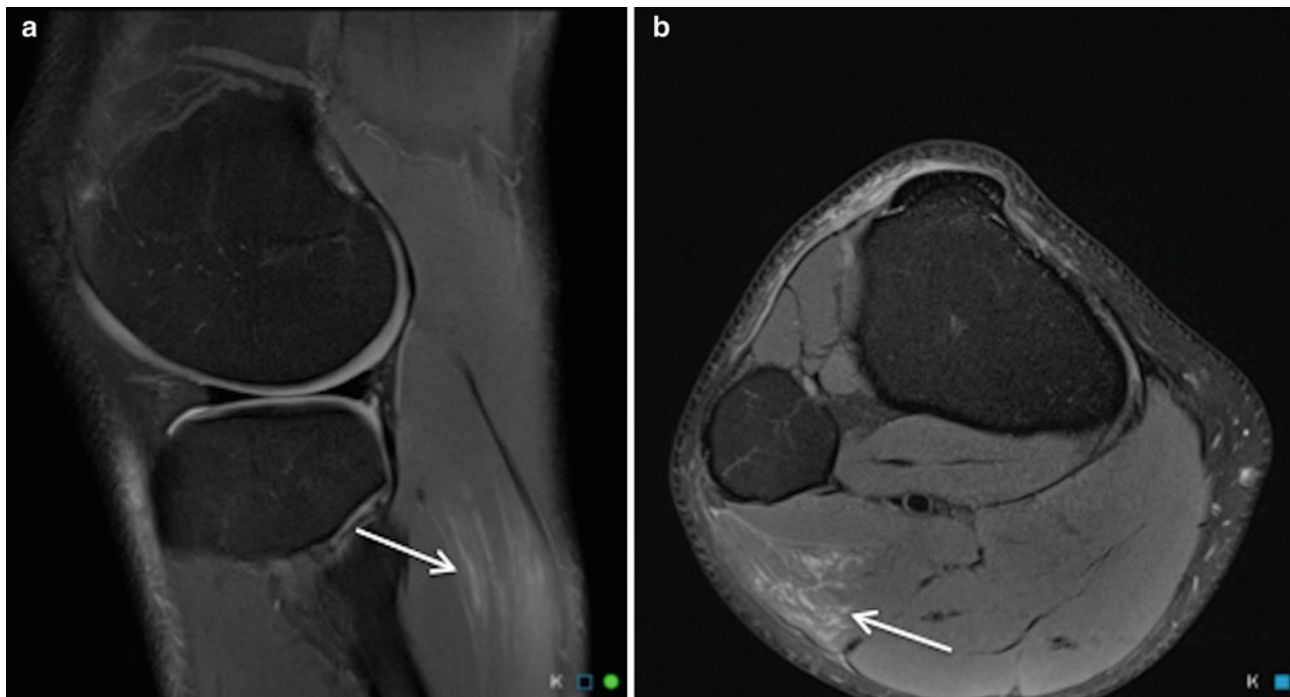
Calf strain. Sagittal (a) and axial (b) proton density weighted MR images with fat saturation (b) show a grade 1 injury of the lateral head of gastrocnemius in a professional rugby league player, with feathery intramuscular oedema but no muscle fibre discontinuity (arrows)
